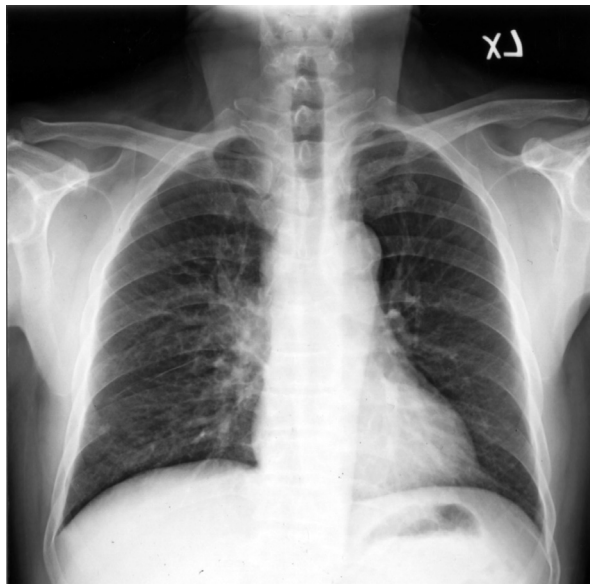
Initial chest x-ray revealed a mass lesion with an irregular border at the right hilum and a widened mediastinum.
